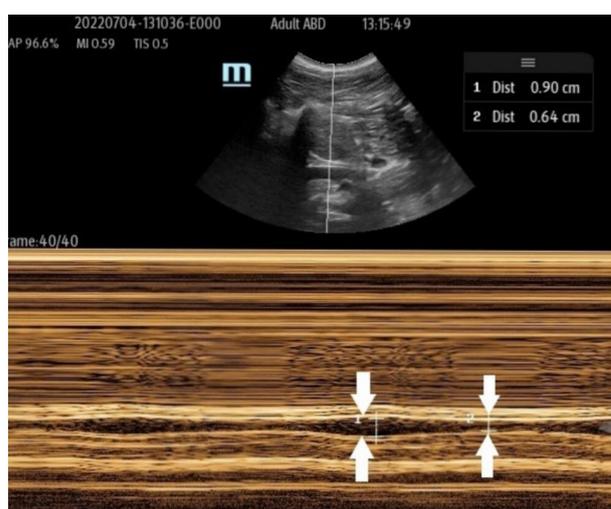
IVC ultrasound image with convex transducer (IVC indicated by arrows): M-mode ultrasound
